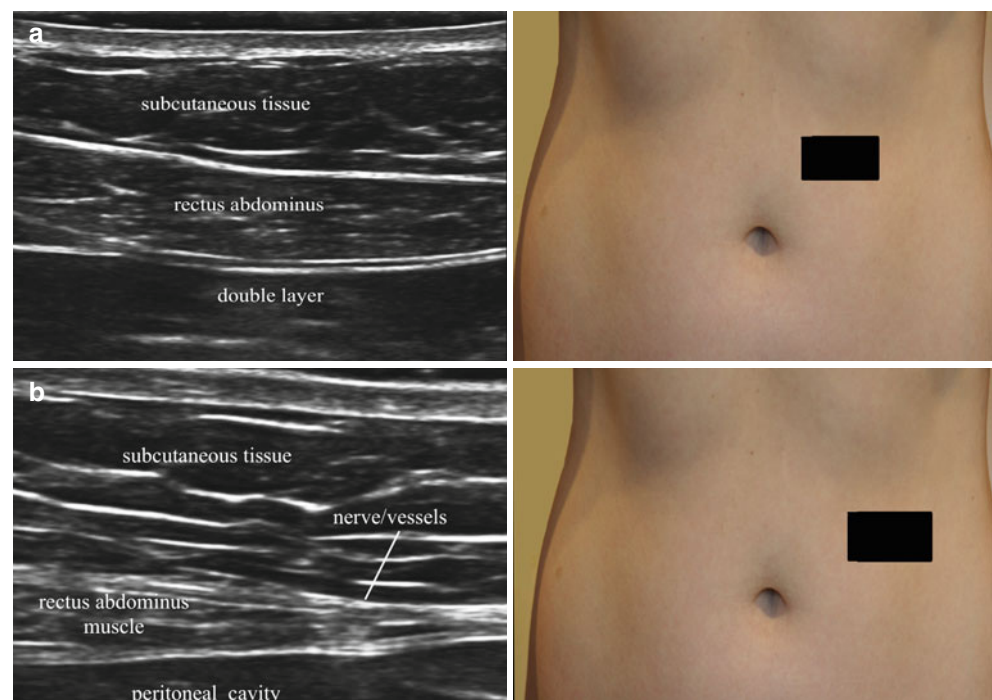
Ultrasound images of the rectus abdominis muscle. *A* ultrasound image at the mid-rectus level, *B* ultrasound image at the lateral rectus border (Image courtesy of Andrea Trescot, MD)
